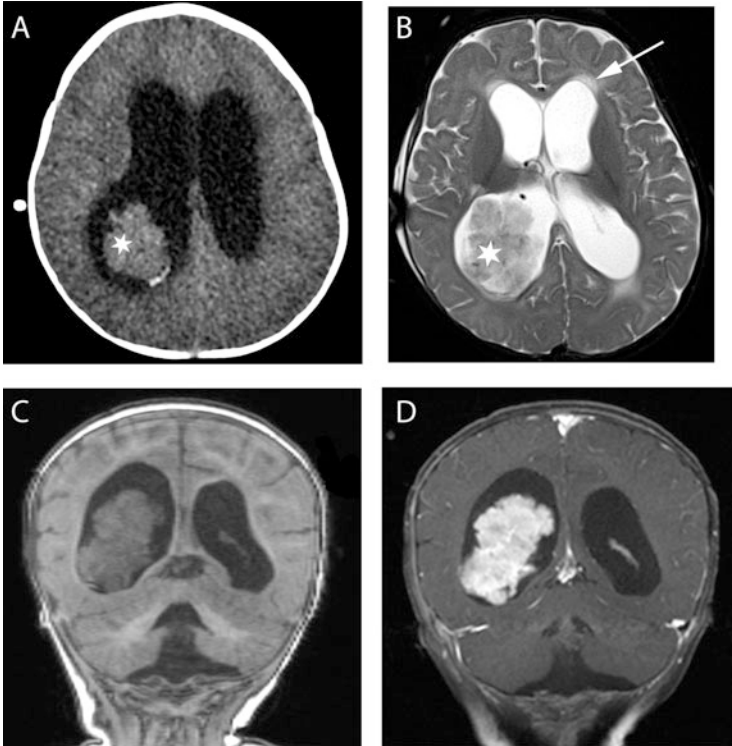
(a) Axial image in a non-contrasted CT scan of the head in a 5 month-old child shows hydrocephalus with a choroid plexus papilloma in the right lateral ventricle that is isodense to surrounding brain and shows a small amount of bright calcification on the posterior border (star). (b) Axial T2-weighted MRI in the same patient demonstrates the tumor (star) and transependymal flow (arrow), the bright area around the frontal horn of the ventricle indicative of elevated intraventricular pressure from hydrocephalus. (c) Coronal non-contrasted T1-weighted MRI demonstrates the large tumor in the lateral ventricle. (d) The tumor brightly and homogeneously enhances with gadolinium contrast
